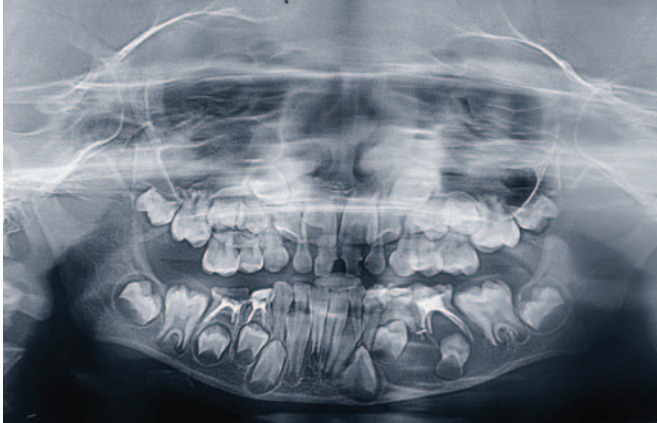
Orthopantomogram showing unilocular, well-defined, radiolucent lesion involving an unerupted mandibular left second premolar.
